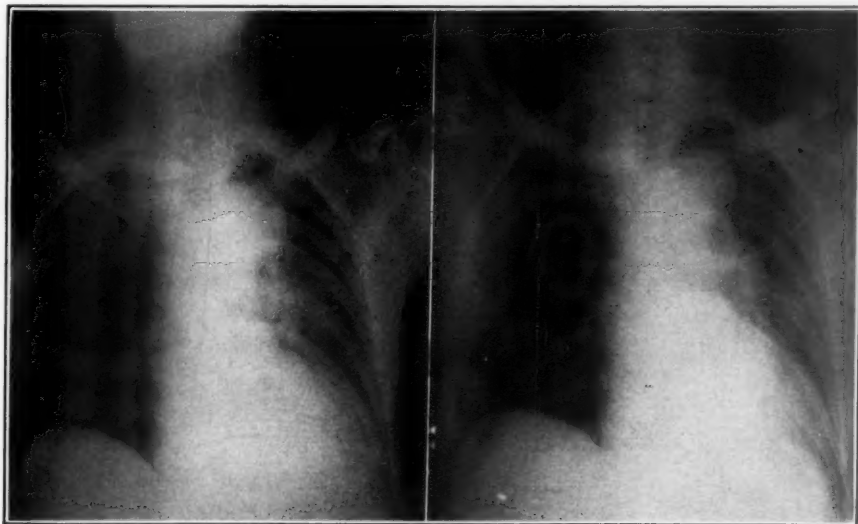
Roentgenograms, anteroposterior projection. The criteria for comparing correctly the two films are not completely fulfilled. The development of a bulging prominence in the course of the descending thoracic aorta, however, is clearly demonstrated. There is also a marked widening in the area which corresponds to the innominate artery.
